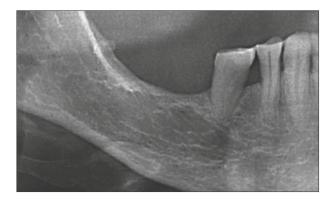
Panoramic radiograph of the edentulous sites 46 and 47. There is barely enough bone available for implant placement above the mandibular canal.
